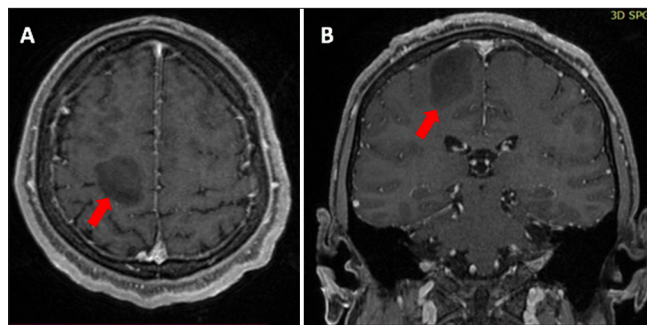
(A) Axial and (B) coronal contrast-enhanced T1-weighted magnetic resonance imaging (MRI) of the head show a hypointense lesion with poorly defined and diffuse borders in the right frontoparietal region indicated by a red arrow.
